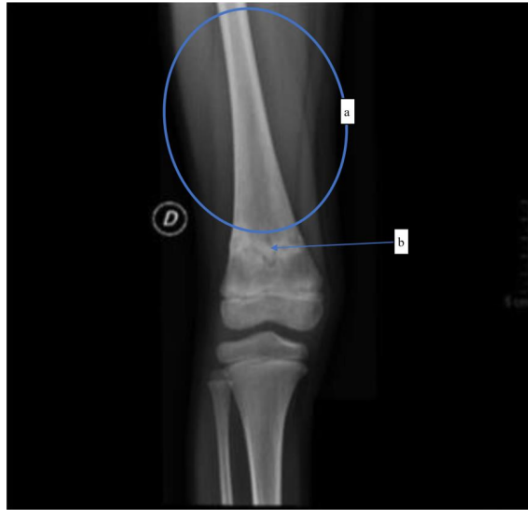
X-ray showing Erlenmeyer flask deformity in right femur (a) and femoral metaphysis stress fracture in the healing phase (b).
